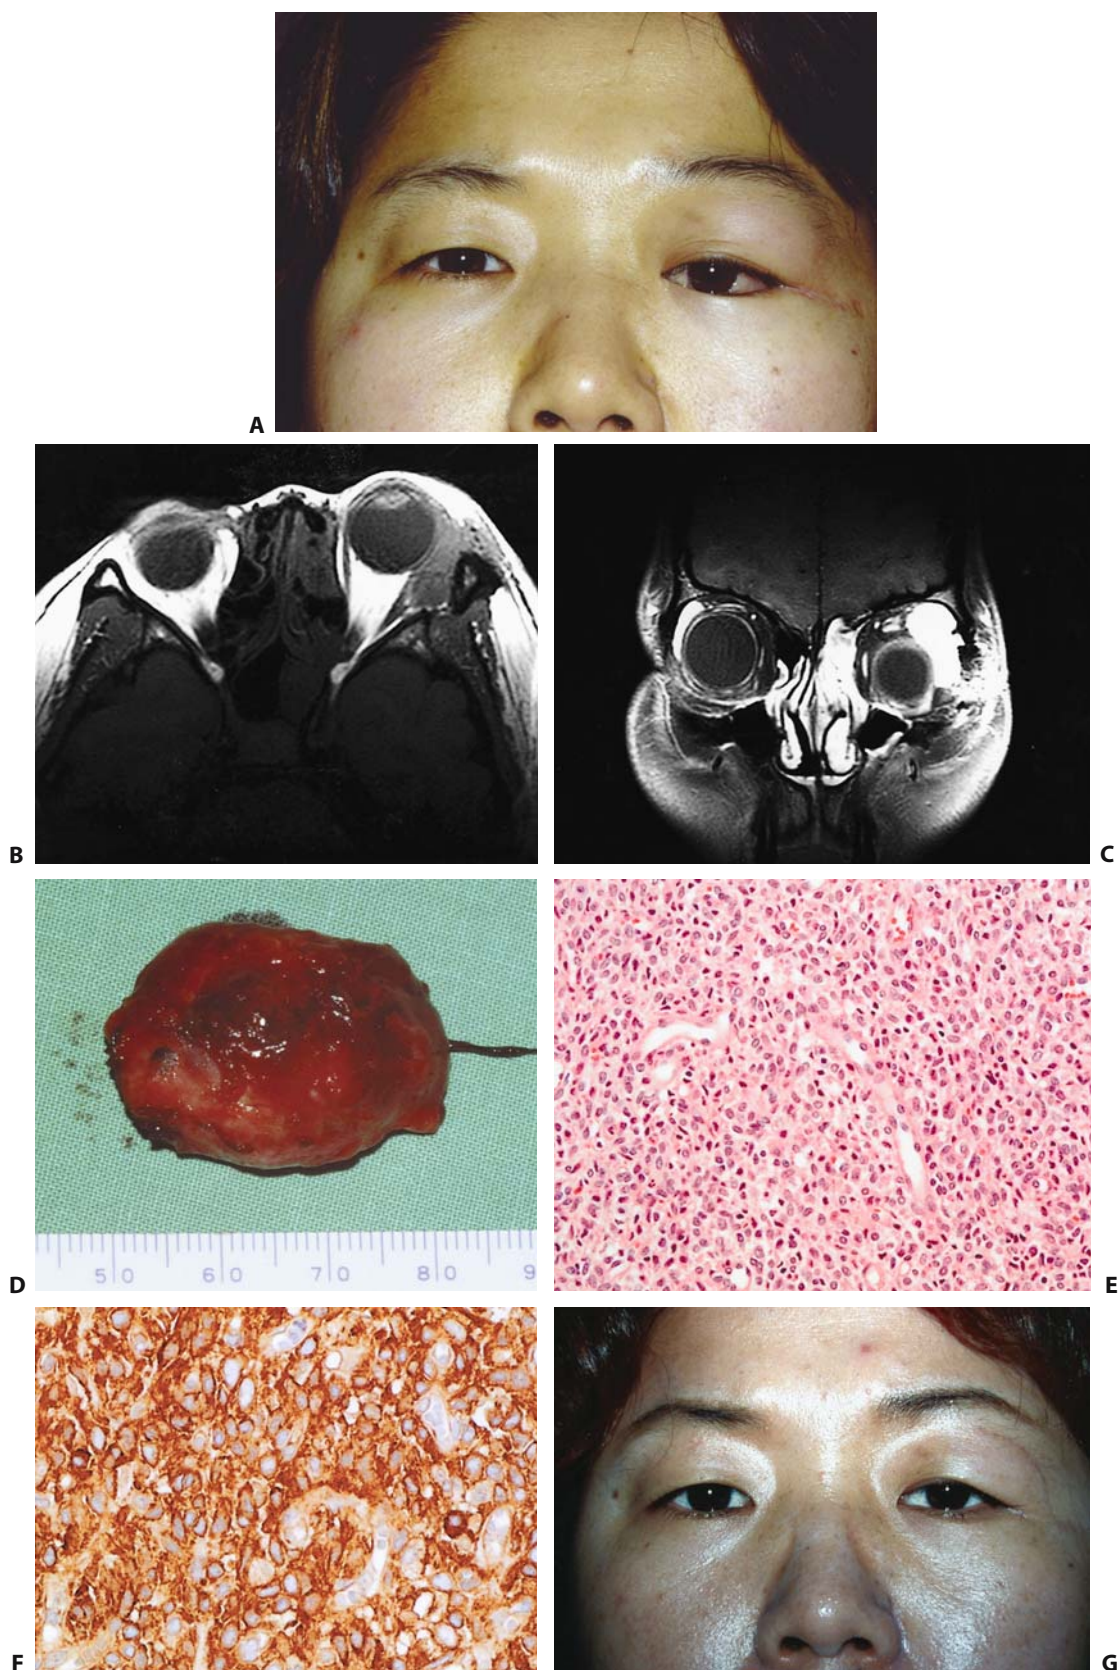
Solitary fibrous tumor. (A) A 27-year-old woman had eyelid swelling, chemosis, proptosis, and inferior displacement of left eyeball for 9 months. Three months before referral, she had undergone incomplete tumor removal via lateral orbitotomy. (B) T1-weighted axial image shows well-demarcated oblongated lacrimal gland mass of low signal intensity. Lateral orbital wall is deformed from previous orbitotomy. (C) T1-weighted enhanced coronal image shows
